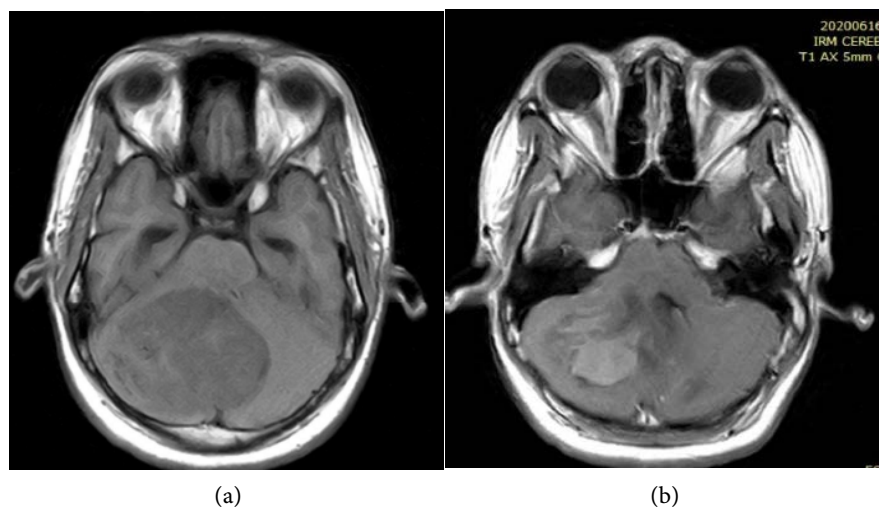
Preoperative MRI showed a right cerebellar tumor compressing the fourth ventricle. (a) T1 without contrast; (b) T1 with contrast.
